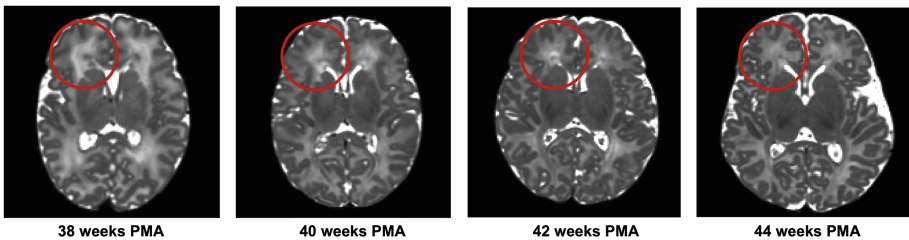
Examples of WM tissue heterogeneity in transient compartments visible on T2w neonatal brain MRI at different PMA (the datasets are from dHCP project [1]).
